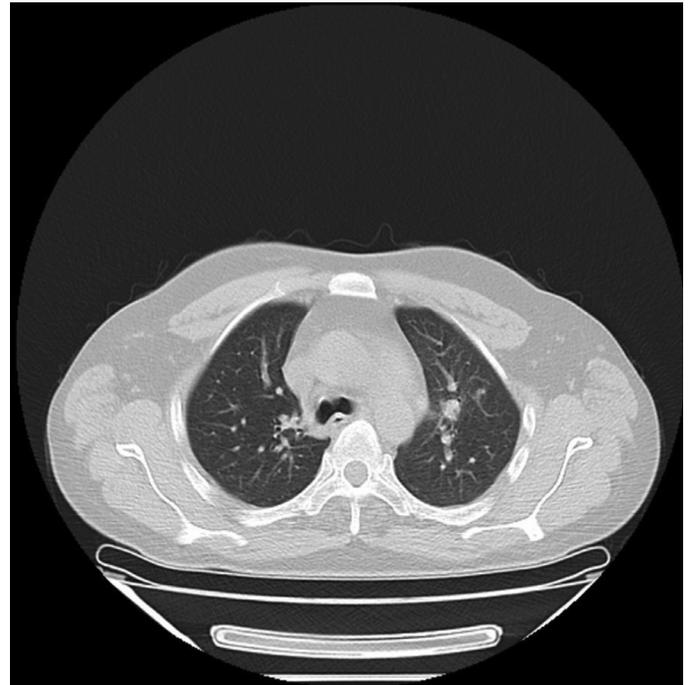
There was no significant pathological change in computed tomography
